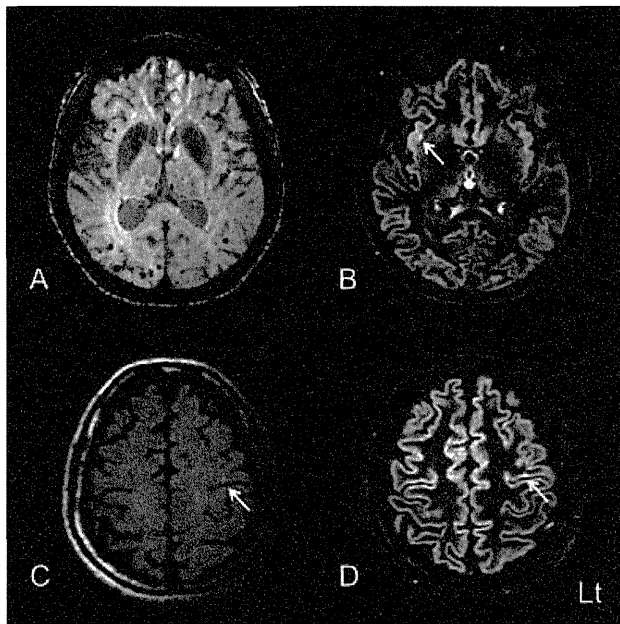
Head MR images in a 41-year-old woman with familial AD (Patient 2). SWI shows multiple lobar CMBs (A). DIR (B, D) and 3D-FLAIR (C) images show small intracortical hyperintense foci in the insular cortex and the left frontal lobe. Arrows indicate intracortical hyperintense foci (B, C, D).
